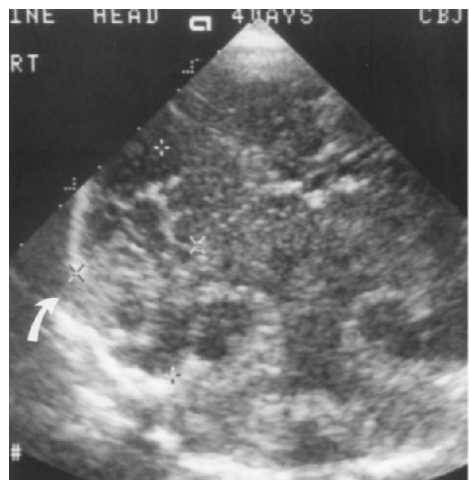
Infant placed on ECMO for a congenital diaphragmatic hernia. Sonogram obtained at 10 days of age shows a 2-cm hypoechoic lesion in the right occipital lobe with surrounding hyperechoic margins consistent with a hemorrhage (*arrow*). The infant died of progressive hypoxemia and autopsy confirmed the presence of a right-sided occipital hemorrhage.
